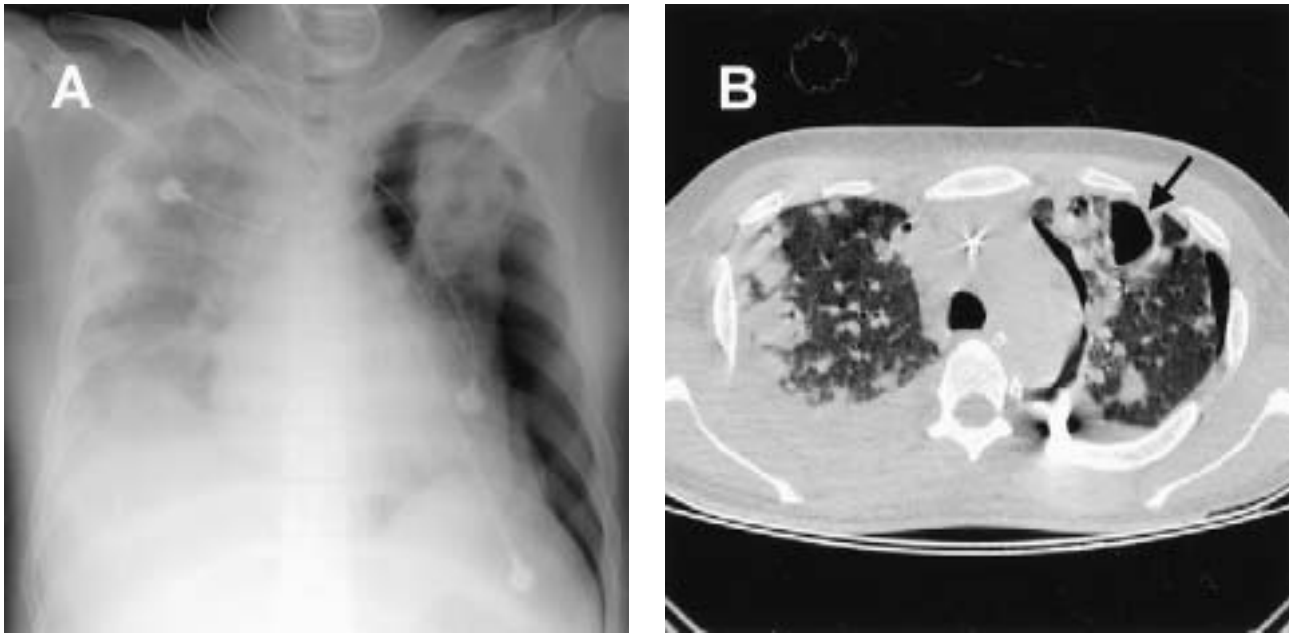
Image studies on the day of spontaneous pneumothorax. (A) Chest radiograph taken immediately after the onset of respiratory distress demonstrated left pneumothorax. (B) CT scan performed after chest tube insertion showed incomplete lung expansion as well as progression of bilateral nodular infiltrations and subpleural cavities (arrow).
